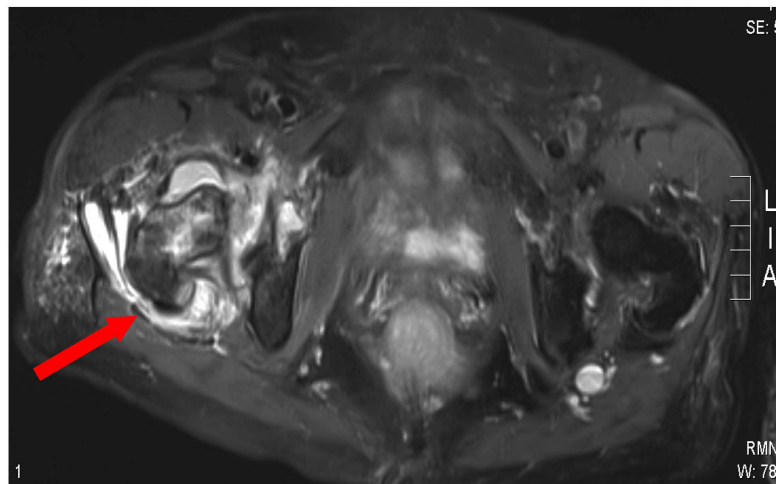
MRI of the hip, T2 images.
